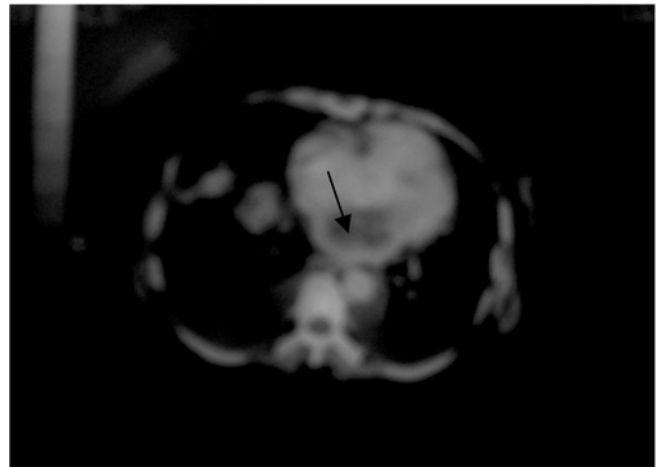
Computed tomographic image of the left atrial mass and bilateral pleural effusion.
